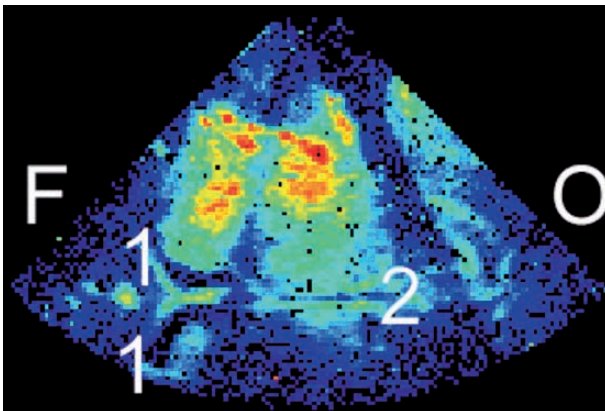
Parametric image, generated after ipsilateral transtemporal axial ultrasound images were acquired as a 1 ml bolus of contrast agent (Optison™) through the intracranial circulation. F: frontal, O: occipital, 1: anterior lateral ventricles, 2: third ventricle. Reproduced with permission from Hölischer et al. (2002).
